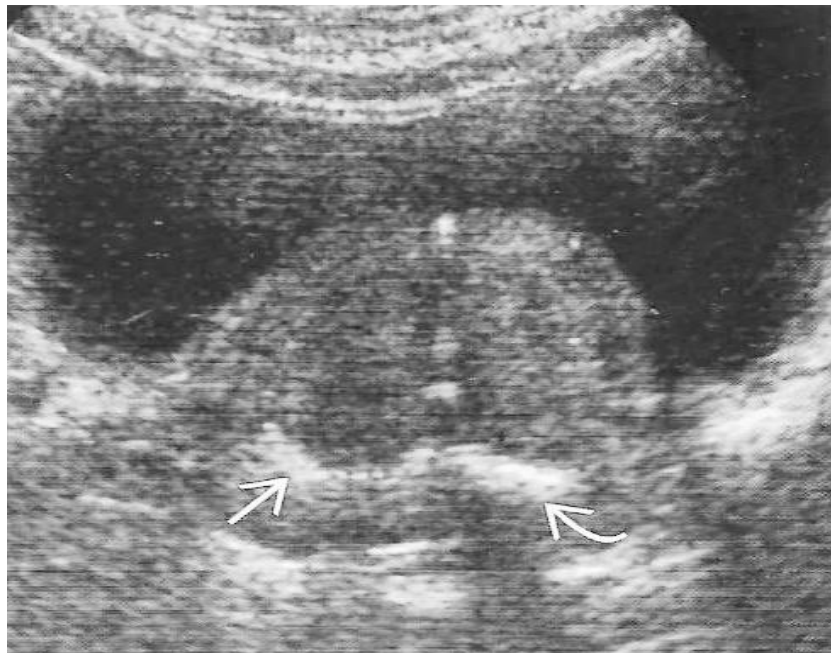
Shows a trans rectal ultrasound image of chronic prostatitis
